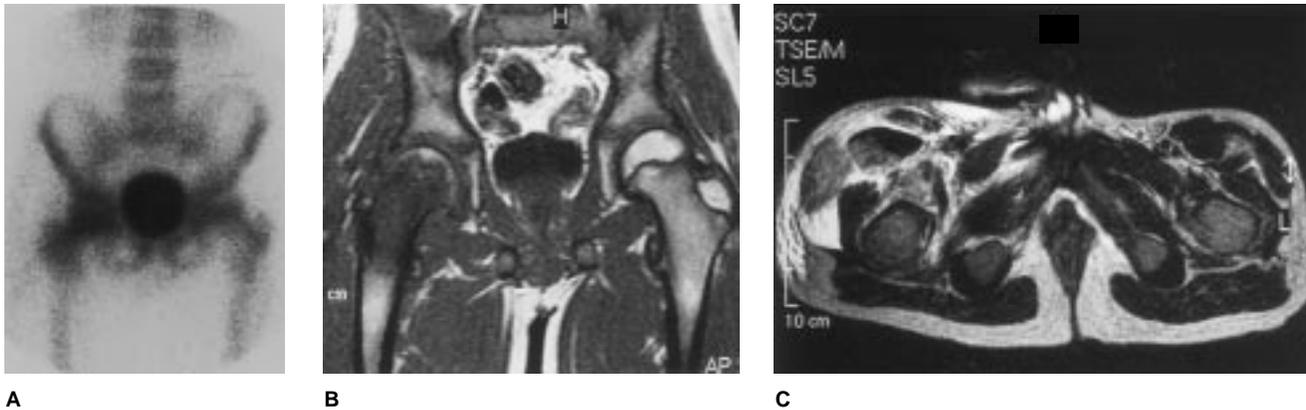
A, Technetium bone scan of a 13-year-old boy with persistent hip pain and a limp for 3 days after receiving a direct blow to the hip. Radiographs were normal. The scan demonstrates increased uptake in the proximal femur. Open arthrotomy was performed on the right hip with drainage of pus and irrigation of the joint. B, A T1-weighted coronal MR image obtained 5 days after arthrotomy, when the patient had persistent fever, hip pain, and swelling despite antibiotic therapy. There is loss of signal in the right femoral head and neck, representing osteomyelitis associated with septic arthritis. C, A T2-weighted fast spin-echo transverse MR image demonstrates considerable soft-tissue edema with residual infection and loss of muscle-plane definition.
